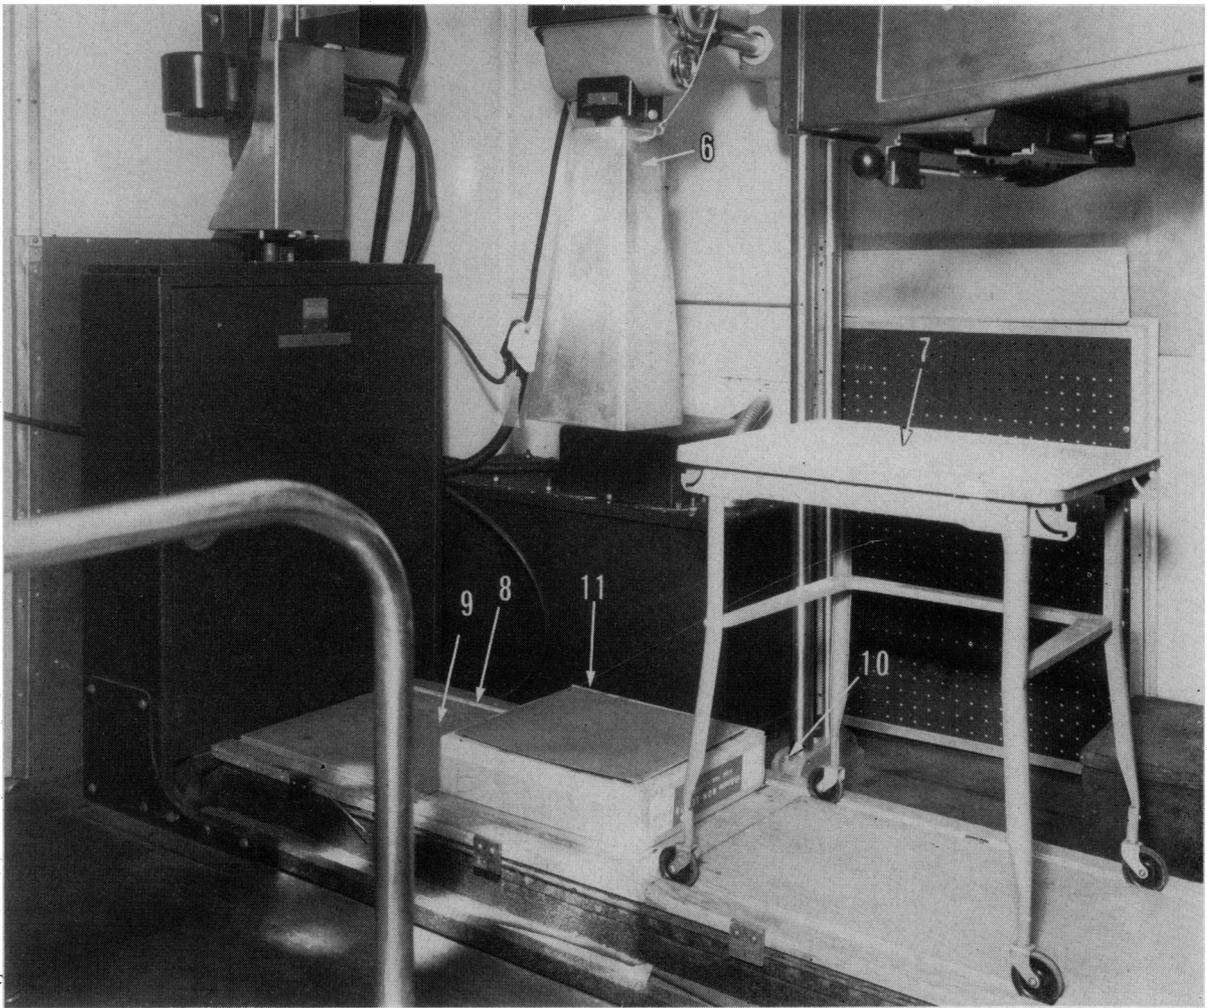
Equipment in position for X-raying feet. Movable table (7) runs in grooves (8) cut in a portable piece of plywood (9); the tube has been lowered to maintain a tube film distance of 40 inches. Screws (10) fasten column to floor. The respondent's feet are placed on a box with lead sheeting (11).
